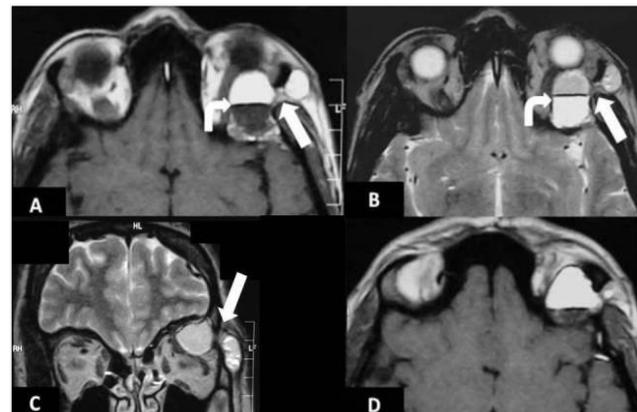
Axial (A) T₁ weighted, and (B) T₂ weighted, coronal (C) T₂ weighted MR images show dumbbell-shaped lesion with a well-defined border (white arrows). There were two layers in the cyst, with reverse signal between the up and down layers on the T₁ weighted and T₂ weighted images. This appearance was consistent with fat-fluid level (curved arrows). (D) Axial post-contrast T₁ weighted image shows a mild marginal contrast uptake around the lesion.
